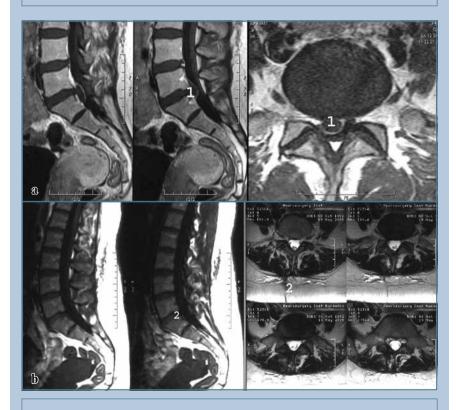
MRI of the patient with the right intervertebral disc hernia at the L5–S1 level:  $\bf a$  – before surgery;  $\bf b$  – 3 months after surgery, no hernia is detected
